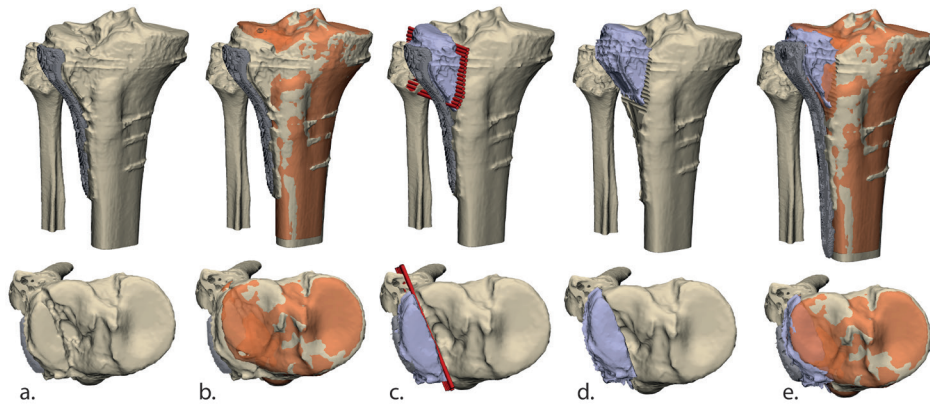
Process of 3D virtual surgical planning. a.) 3D reconstruction of the affected bone is created from the CT-scan. b.) The contralateral unaffected side (orange) is mirrored and aligned to serve as a template for reduction. c.) The osteotomy cut (red) consisted of several drill trajectories and is planned to cut the malpositioned fragment. d.) the malpositioned fragment is virtually reduced to its anatomical position. e.) The new position is verified with the matching of the mirrored contralateral side.
